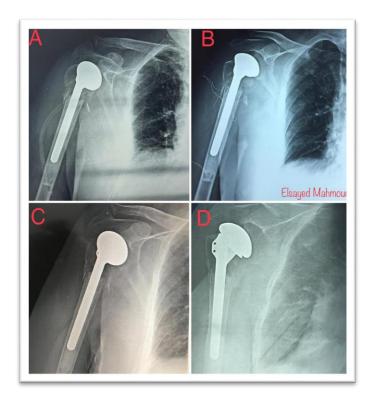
Postoperative X-Rays. A: Immediate postoperative X-Ray, B: 6 weeks after surgery, C:3 months after surgery. D:Final X-Ray 14 months after surgery showed concentric joint reduction, neutral stem position, adequate cementation and united tuberosities in anatomical position.
